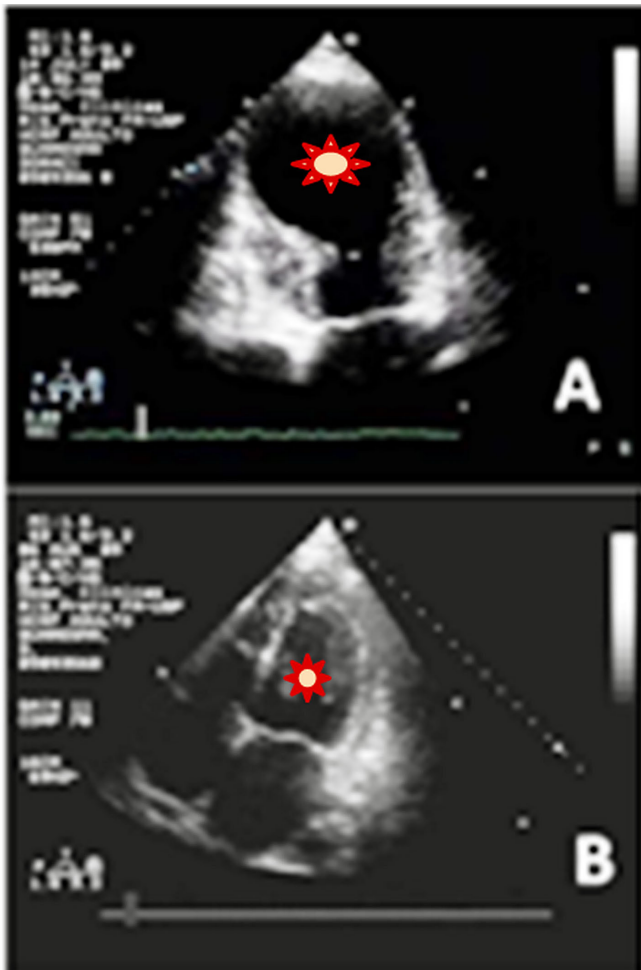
Echocardiogram. A) Presence of a large aneurysm of the left ventricular apex; B) Mild dilatation of the left atrium with other cardiac chambers of normal size. Note the postoperative elliptical shape of the left ventricle (2 years after surgery).
